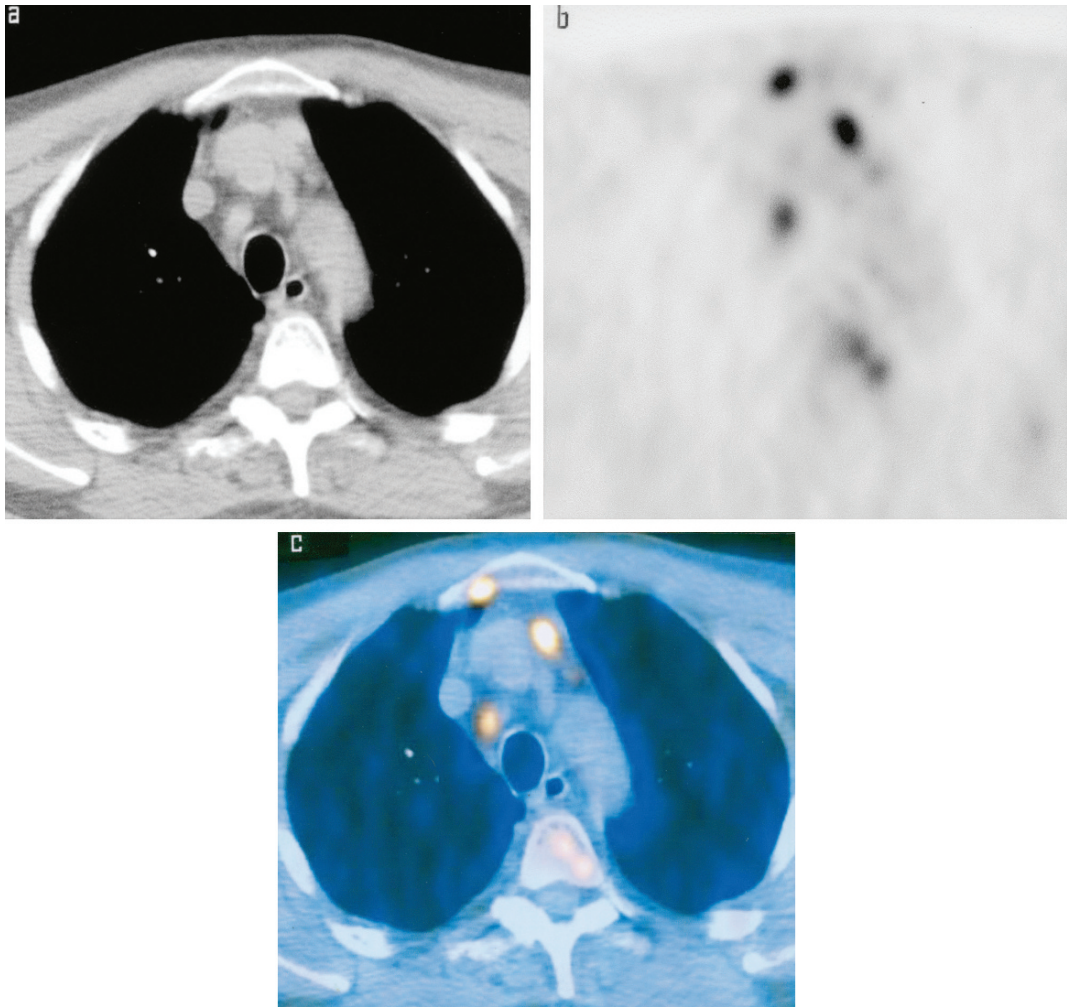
FDG PET-CT scan of the thorax at the level of the aortic arch in a patient with recurrent melanoma. (a) CT component demonstrates small lymph nodes less than 1 cm in the anterior mediastinum and anterior carinal region which would not be regarded as suspicious for recurrence using anatomical criteria alone. No other significant abnormality is seen. (b) Corresponding PET component (attenuation corrected image) shows increased abnormal FDG uptake in the lymph nodes of normal size, and also in the sternum on the right. Moderate increased uptake in the vertebral body represents marrow activity. (c) Fused image accurately confirms the anatomical site of the increased FDG uptake in the lymph nodes and the bone metastasis in the right sternum despite the apparently normal CT appearances
